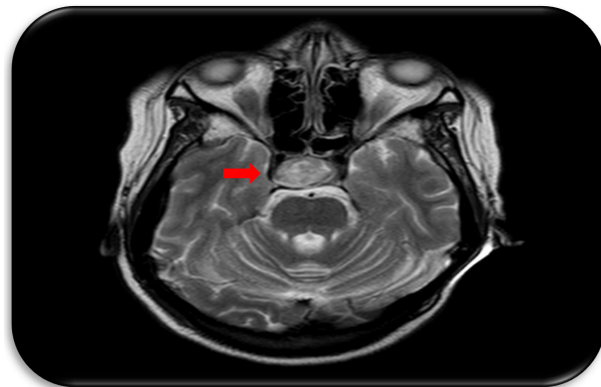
Brain MRI. Enhancing suprasellar mass 2.2 cm × 1.9 cm × 2.5 cm with possible invasion into the right cavernous sinus and mass effect upon the optic chiasm
